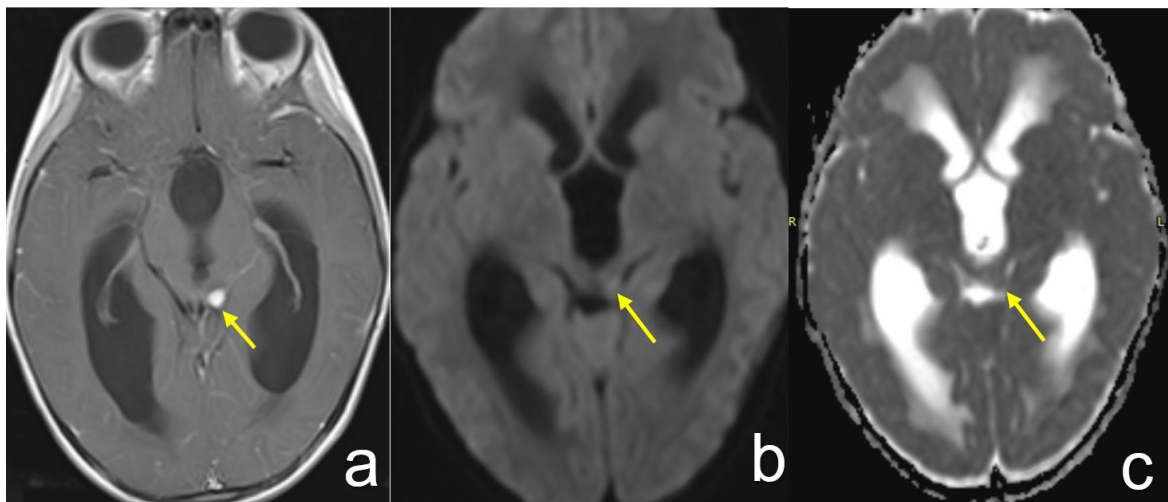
Contrast enhanced T1 axial (a), DWI(b) and dADC (c) images of a 4 year old with medulloblastoma (subtype unknown), showing an enhancing leptomeningeal nodular drop metastasis in the left ambient cistern, with slightly hyper intense signal on DWI but iso intense signal on ADC map (arrows) suggesting absence of diffusion restriction on visual inspection. The primary mass showed diffusion restriction(not shown here).
